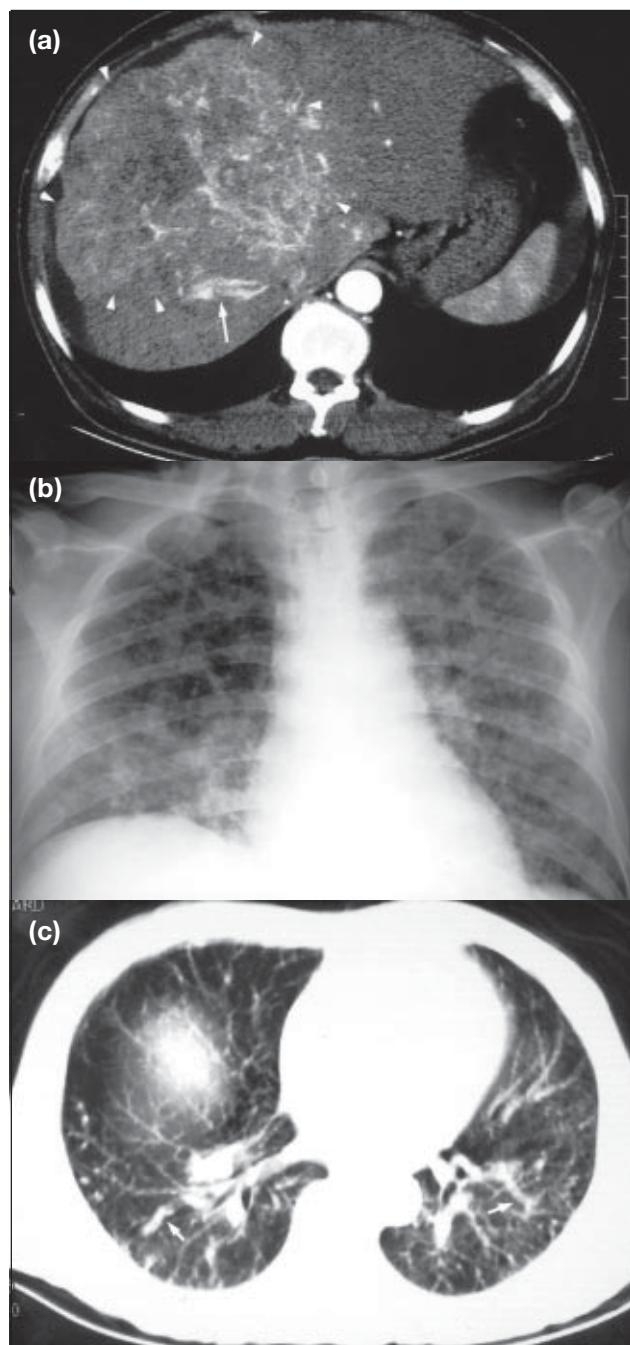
Computed tomography and X-ray findings in case 2
